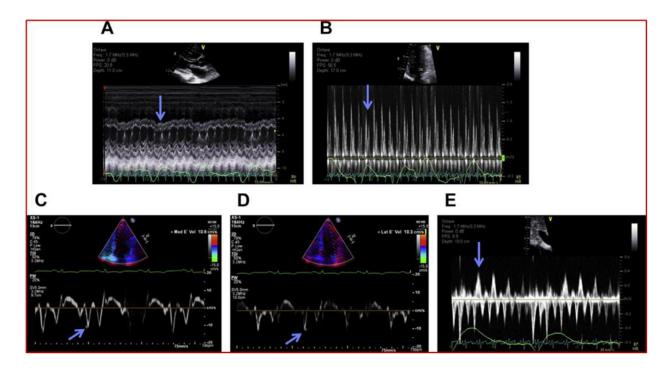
Principal echocardiographic findings in constrictive pericarditis.(A) Leftward ventricular septal shift in inspiration (arrow). (B) Inspiratory decrease in early (E) inflow velocity (arrow) at Pulsed-wave Doppler. (C) Medial and (D) lateral mitral annular tissue Doppler recordings. Note (arrows) normal to increased early relaxation velocity (e'), with medial velocity slightly greater than lateral. (E) Pulsed-wave Doppler recording within the hepatic vein. Note prominent end-diastolic flow reversals with expiration (arrow) [14].
